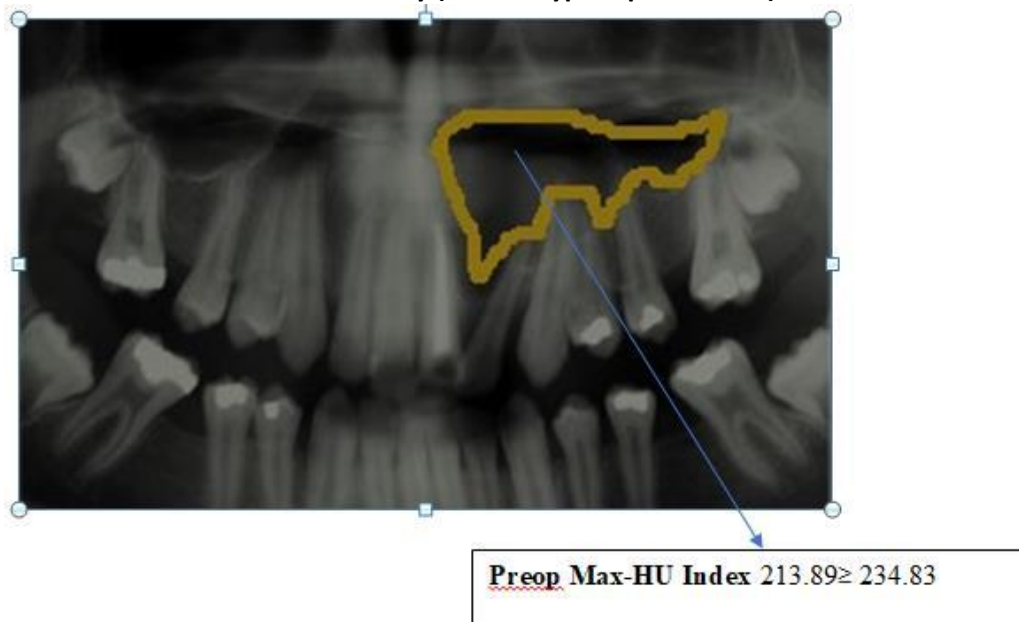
Maxillary Preop Ma-HU Index value at the Center of Bone resorption demineralization radiolucency (Intrabonyperiapical defect)
